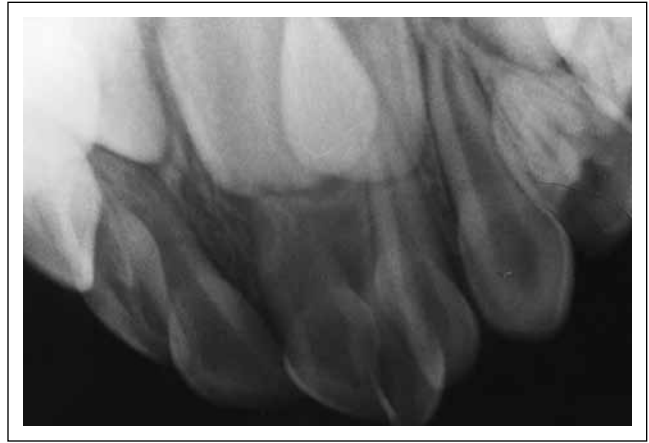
Occlusal radiograph of the triple tooth of case no. 1 showing three differentiated pulpal chambers. Only two root canals can be guessed.
